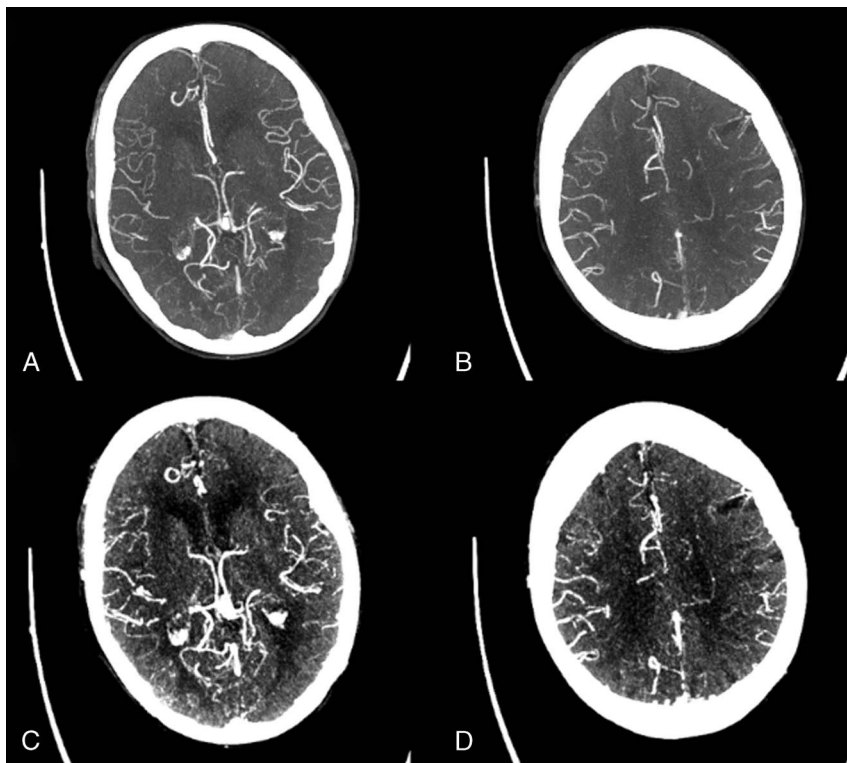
Example case with collateral circulation graded as good by the 2 observers. Single-phase CTA images are shown on ASPECTS levels 1 (A) and 2 (B). Three-phase CTA images were created from PCT source data. The first phase of the 3-phase CTA images is shown on ASPECTS levels 1 (C) and 2 (D).
